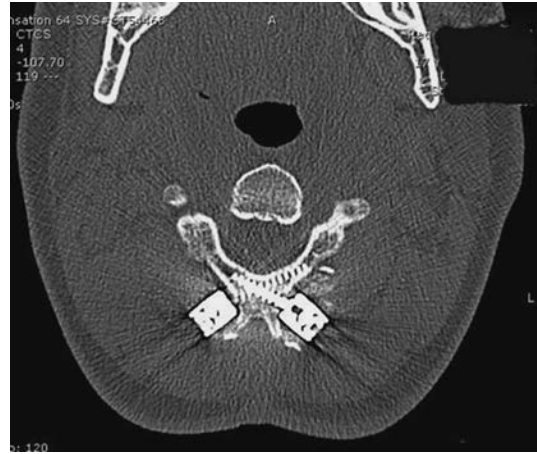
CT shows placement of screws.
